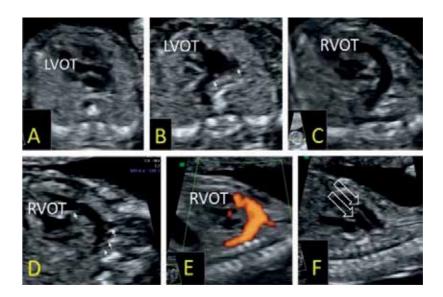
Transposition of the great arteries. (A): Emergence of the vessel arising from the left ventricle, showing early branching (B) that suggest pulmonary outflow tract. (C): Emergence of the vessel arising from the right ventricle with no evident branching in the transversal plane. (D): Sagittal view of the thorax showing branching characteristic to aortic arch of the vessel arising from the anterior ventricle in gray scale and after power Doppler is applied (E). (F): Parallel course of the great vessels.
